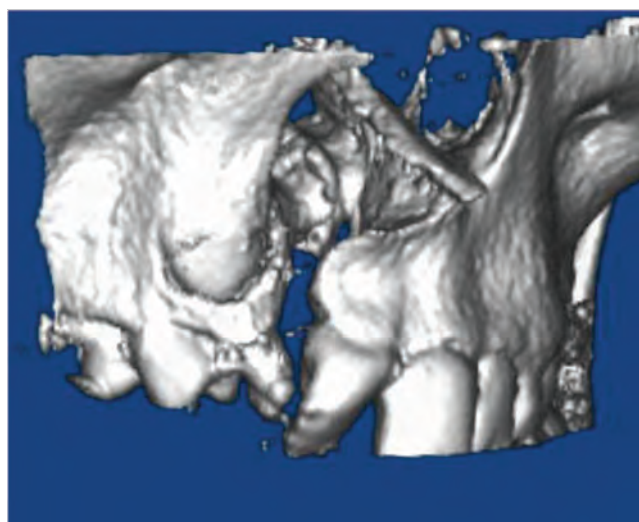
Cone beam computed tomography of right unilateral alveolar defect.
